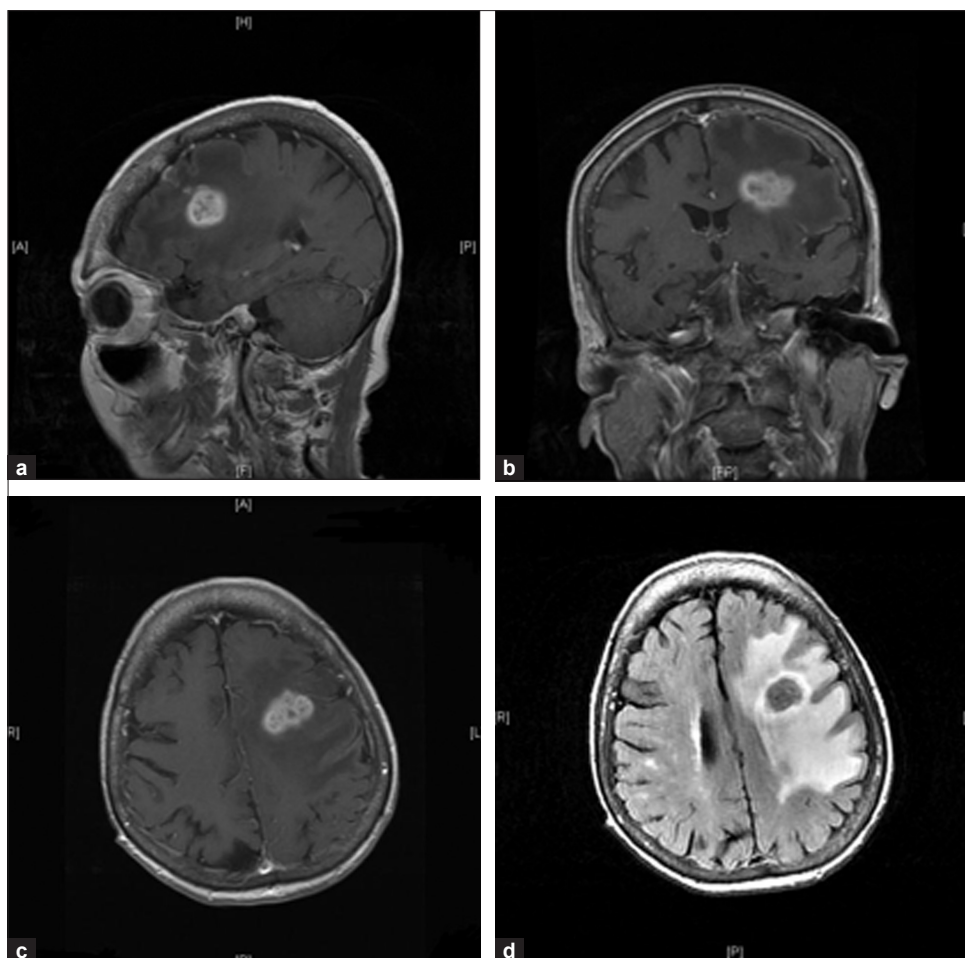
Follow-up MRIT post-contrast demonstrate an increase in size of the left frontal lesion with much increased surrounding edema (see FLAIR image right lower panel)
